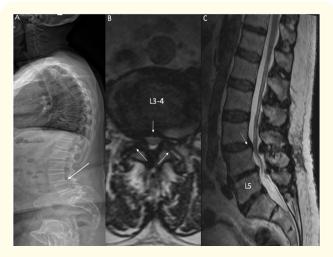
X-ray and MRI imaging of patient from Case 1.
